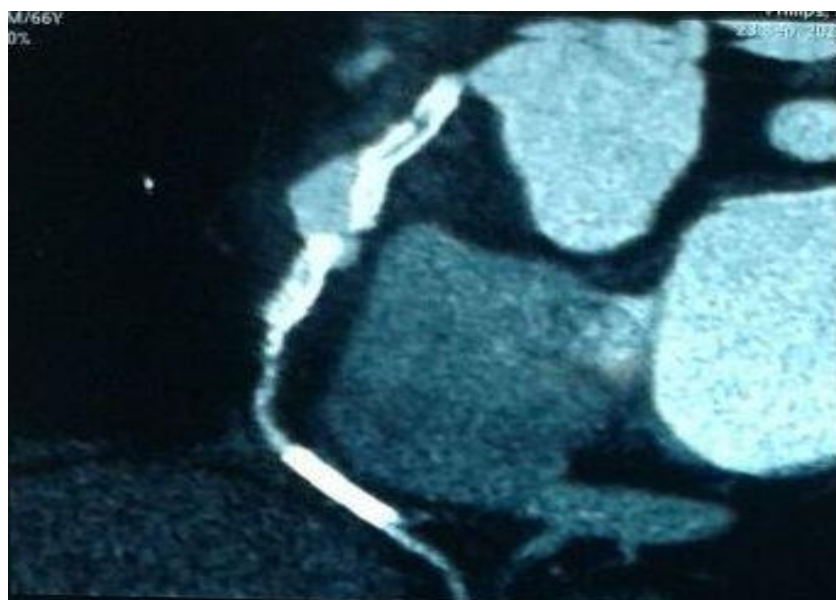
Computed Tomography Coronary angiography showing complete type V stent fracture in proximal Right coronary artery stent.
